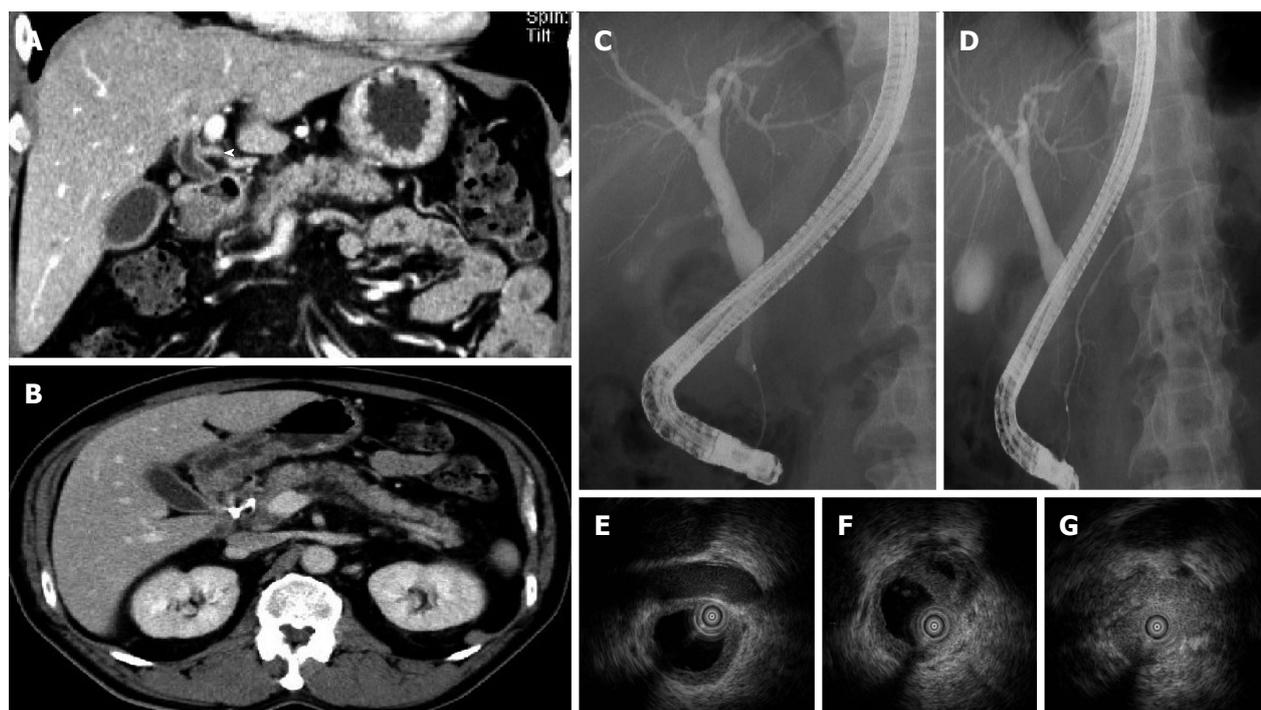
Imaging findings of Case 4. A: Wall thickness of extrahepatic bile duct on abdominal computed tomography (CT); B: Normal size of the pancreas on abdominal CT; C: Stenosis in the lower extrahepatic bile duct on endoscopic retrograde cholangiography; D: Normal main pancreatic duct on endoscopic retrograde pancreatography; E (at the hilar hepatic lesion); F (at the bifurcation of cystic duct); G (at the intrapancreatic lesion): Bile duct wall thickening with smooth inner and outer margin in areas with stenosis (G) and without (E, F) on intraductal ultrasonography.
